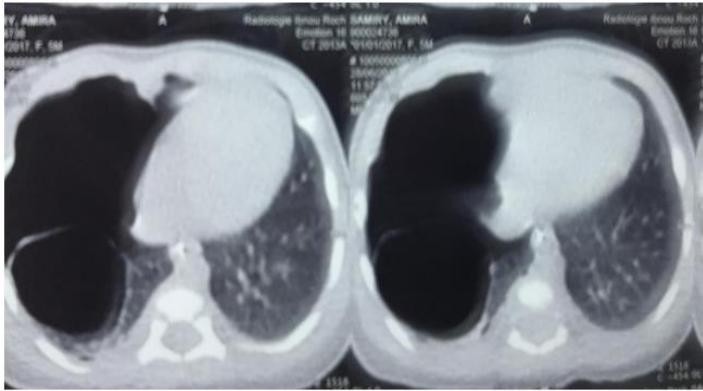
Thoracic CT scan showing adenomatoid cystic malformation stocker's type I.
